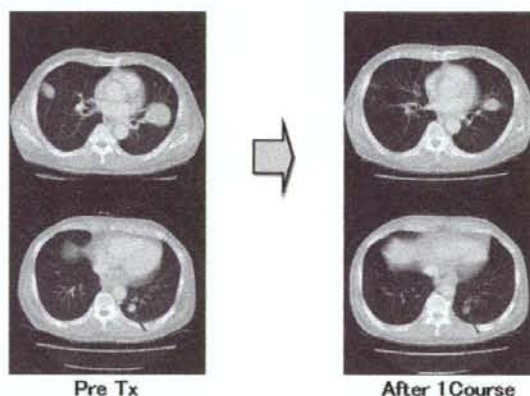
CT scan of an esophageal cancer patient with lung metastasis. This patient had previously undergone 5-FU+CDDP followed by taxotere. Partial response, characterized by a more than 50% decrease in size of the lung metastasis compared with the baseline scan (43).
